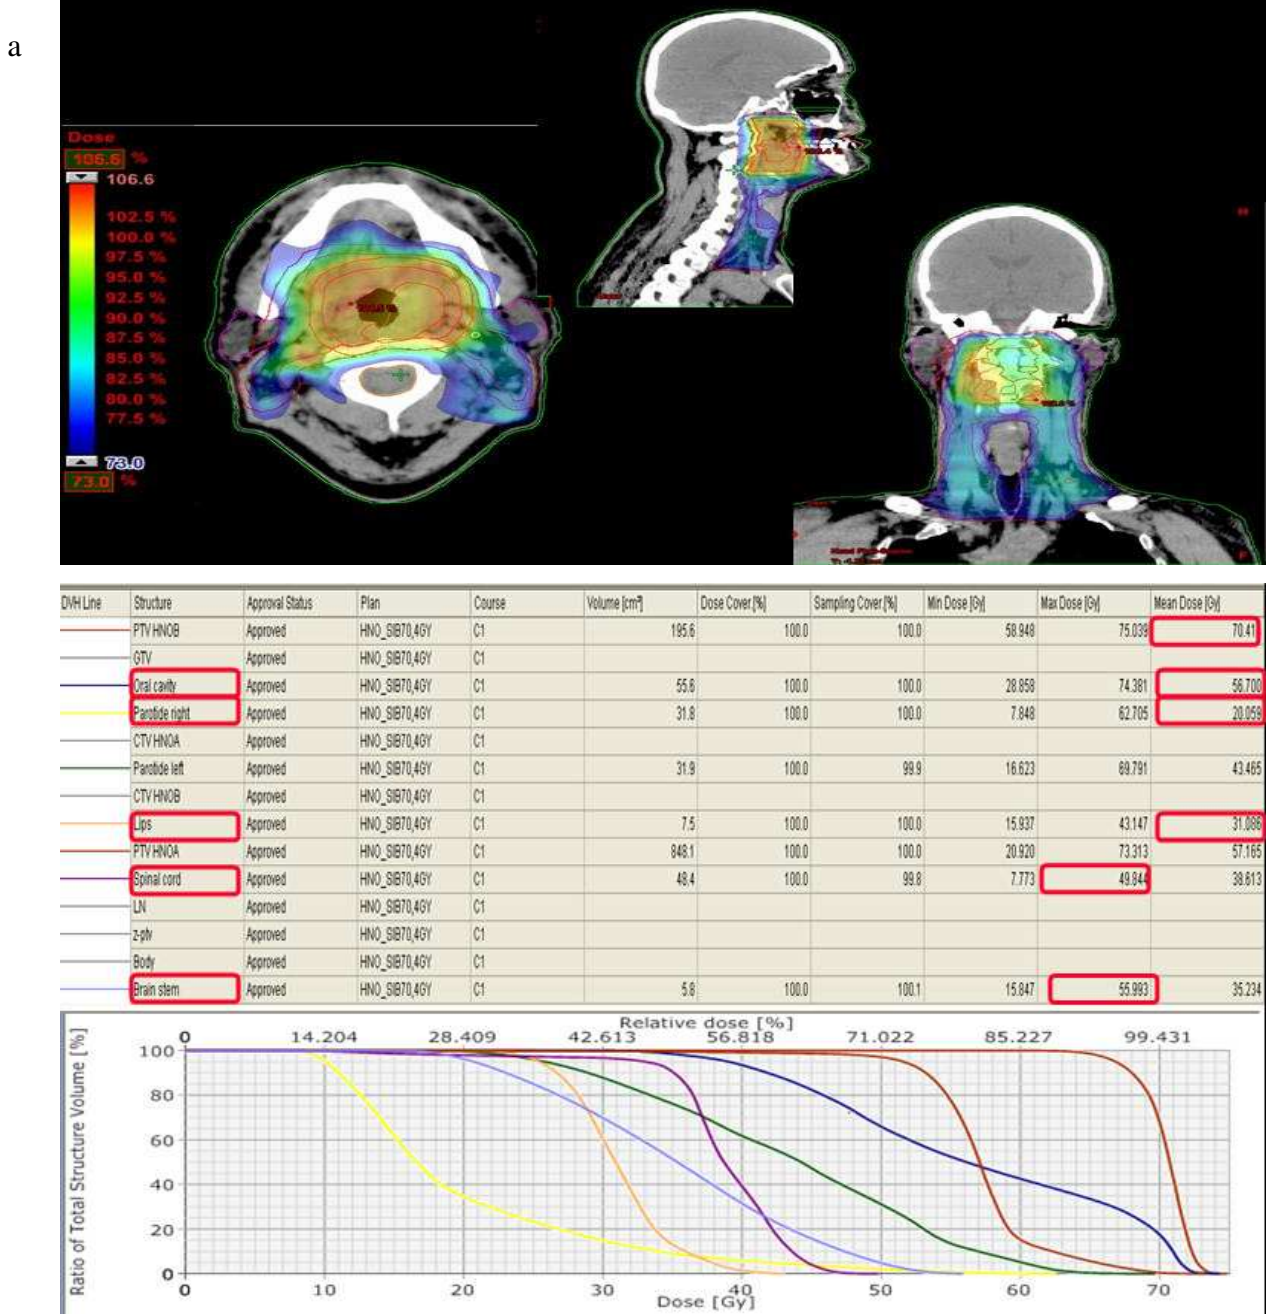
SIB-IMRT plan using 9 coplanar fields with 6-MV x-rays delivered a total dose of 70.4 Gy to the PTV_C (gross tumor) at 2.2 Gy /fraction, and 54.4 Gy for prophylaxis to PTV_A (low-risk) at 1.7 Gy/fraction over 32 fractions: (a) Dose colour wash analysis displayed in axial, coronal, and sagittal images. (b) Absolute and relative DVH showed dose received by target volumes and different OARs (contralateral right parotid gland received D_{mean} 20.06 Gy).
